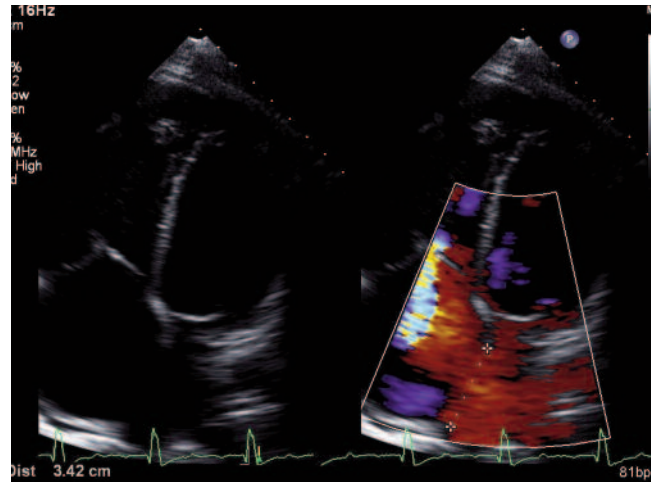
Apical four-chamber echocardiography showing large secundum atrial septal defect with left to right flow on colour Doppler.
